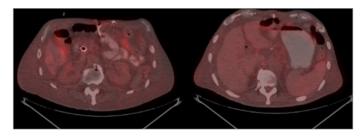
Control PET-CT - The prominent remission of the disease after 8 cycles of Gemcitabine-Nab-Paclitaxel.
